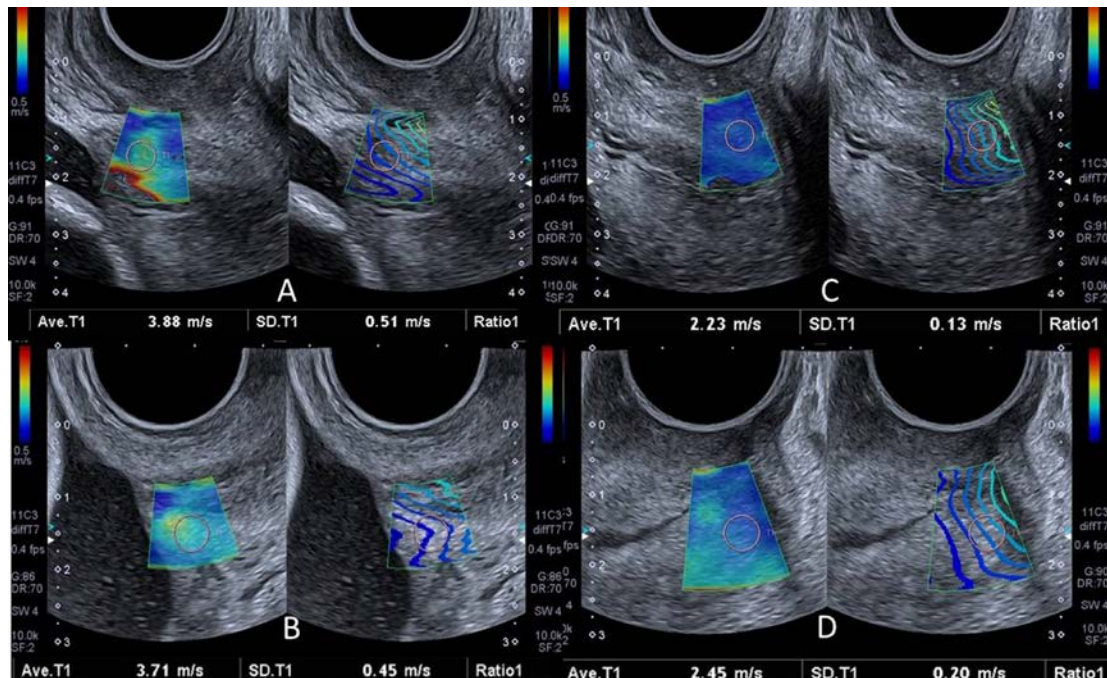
Example of elastogram and ROI placement for the transvaginal ultrasound approach. SWS (and SD) obtained as follows: A - Anterior Internal os 3.88m/s (SD 0.51m/s), B - Posterior Internal os 3.71m/s (SD 0.45m/s), C - Anterior External os 2.23m/s (SD 0.013m/s), D - Posterior External os 2.45m/s (SD 0.20m/s).
